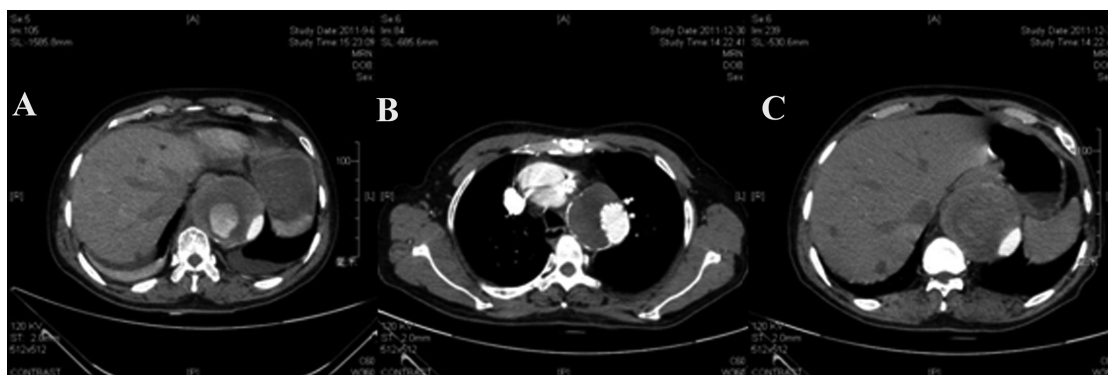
Computed tomography (CT) images of the false lumen. A) A large false lumen was identified in the abdominal aorta before surgery. B) At 3 month postoperatively CT revealed thrombosis in the descending false lumen and (C) thrombosis in the abdominal false lumen
